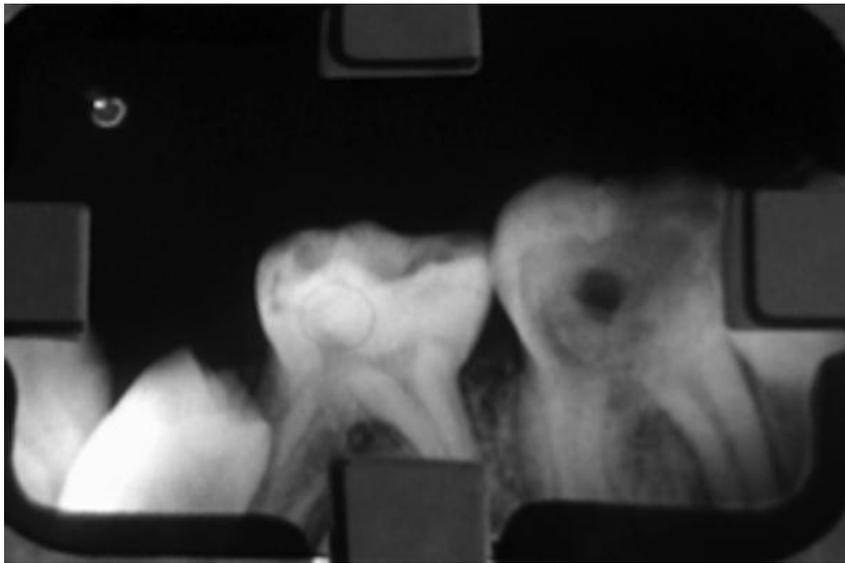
Periapical Rx: tooth 36 with lesion in the furcation region.
